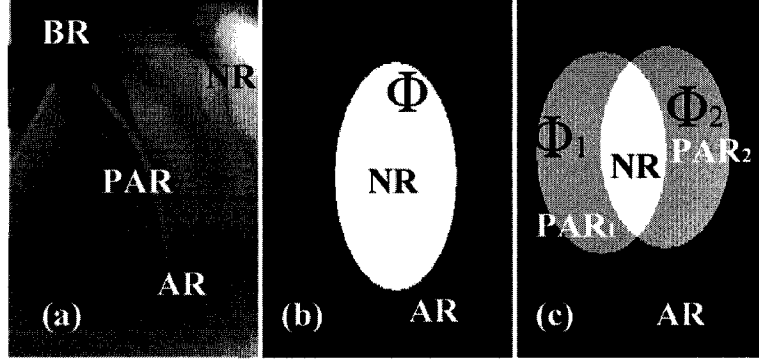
Region modelling. (a) The dental X-ray image can be divided into four regions:  $\Omega_{NR}$ ,  $\Omega_{PAR}$ ,  $\Omega_{AR}$ , and  $\Omega_{BR}$ . (b) With one curve  $C$ , one level set function segments the image into  $\Omega_{NR}$  and  $\Omega_{AR}$ . (c) Two competitive coupled level set functions segment the image into three regions:  $\Omega_{NR}$ ,  $\Omega_{PAR}$  and  $\Omega_{ABR}$ .
